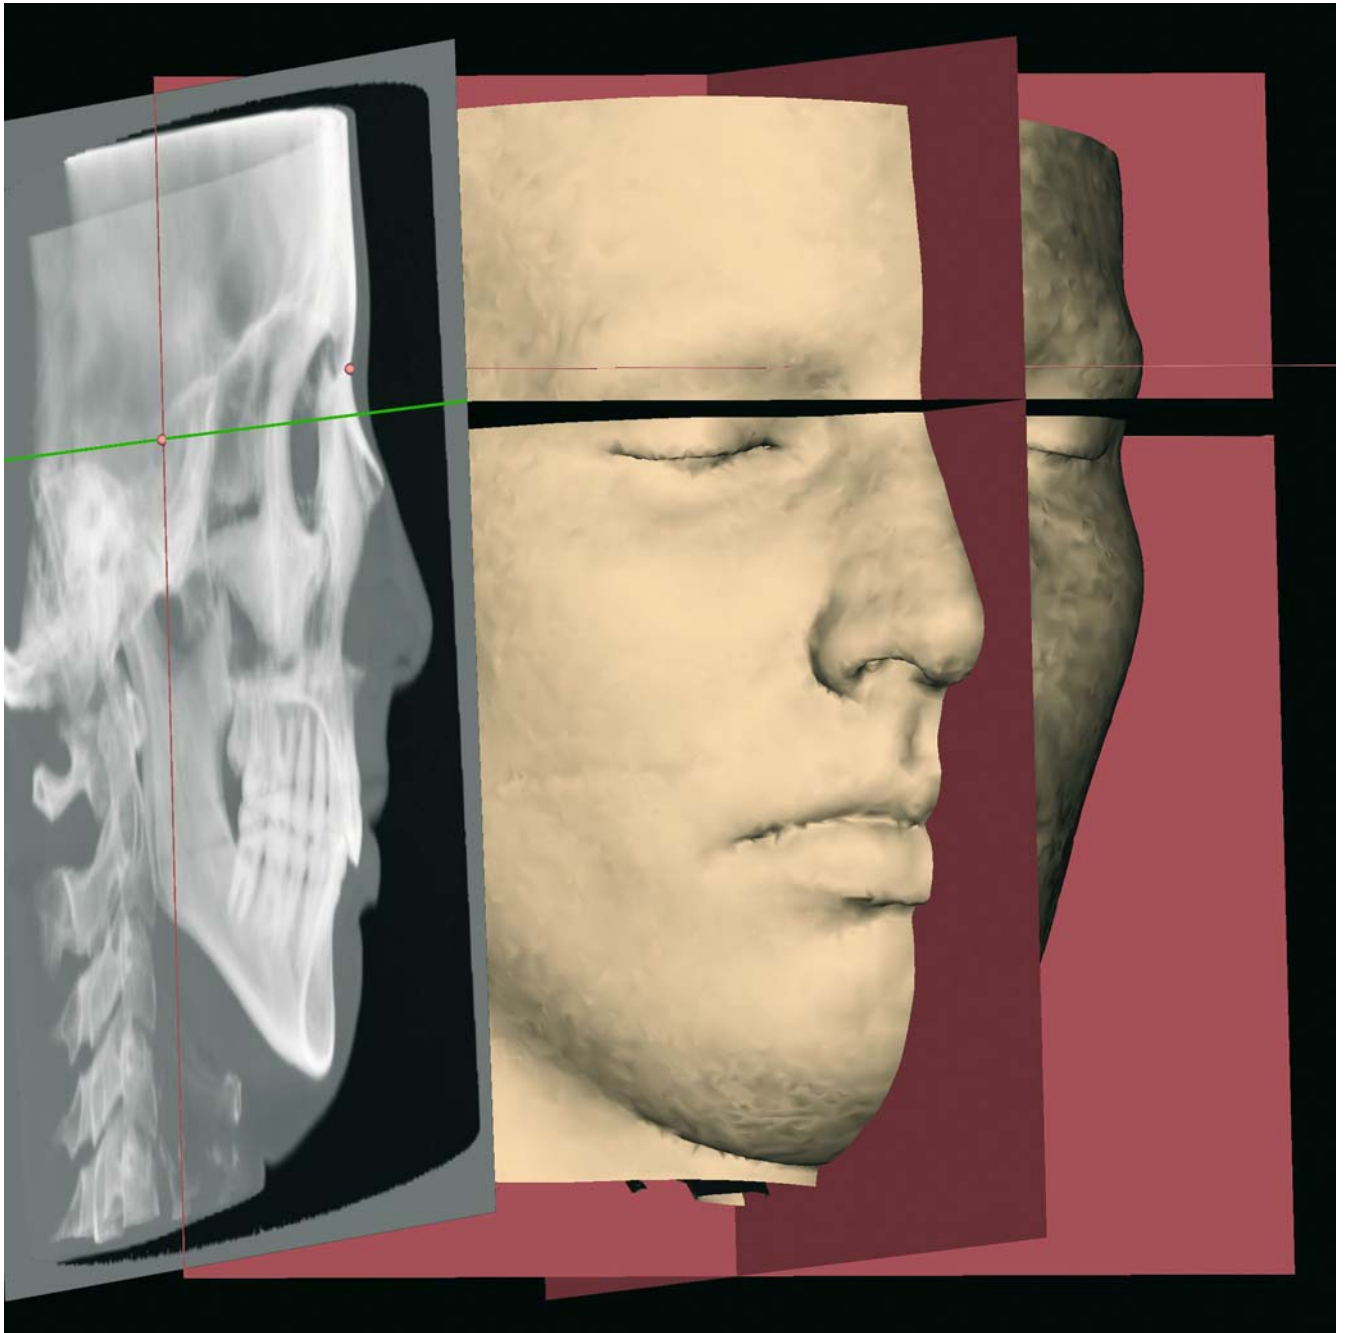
3-D cephalometric reference system. Virtual lateral cephalogram linked to the 3-D soft tissue surface representation (3-D CT, patient K.C.)
